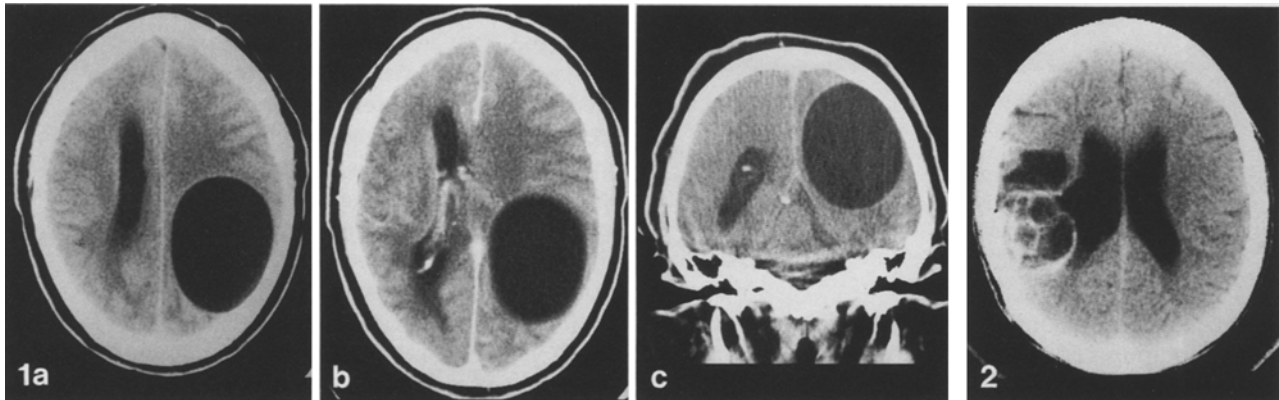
a-c. Case 4: CT scan, plain (a), after contrast (b) and a coronal scan after contrast (c) show a well-defined smooth-walled unilocular cyst with marked shift of midline structures to the right. No calcification, no surrounding oedema and no enhancement are seen
